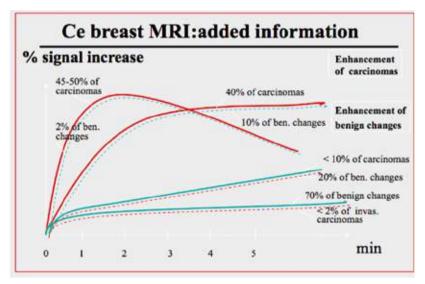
CE Breast MRI: Added Information
